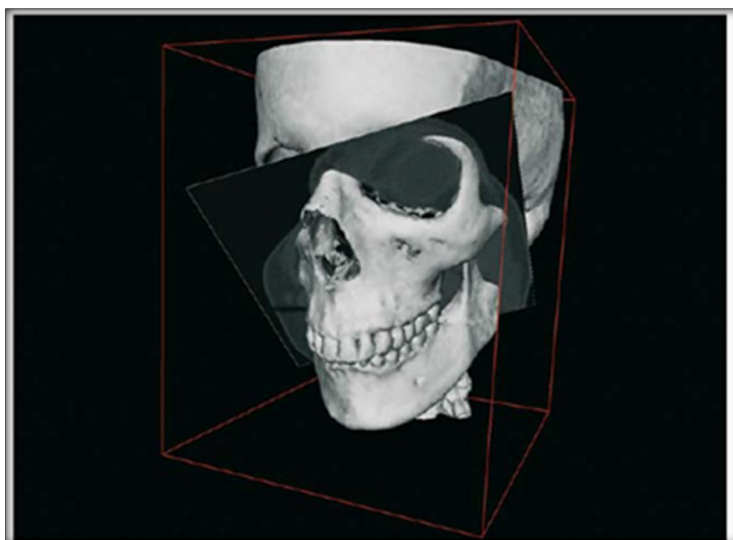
Computing CT numbers and re-slicing
